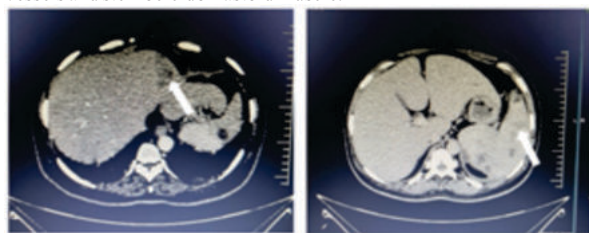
Contrast enhanced CT Abdomen showing hepatosplenomegaly with multiple hypoenhancing lesions suggestive of abscess formation.
